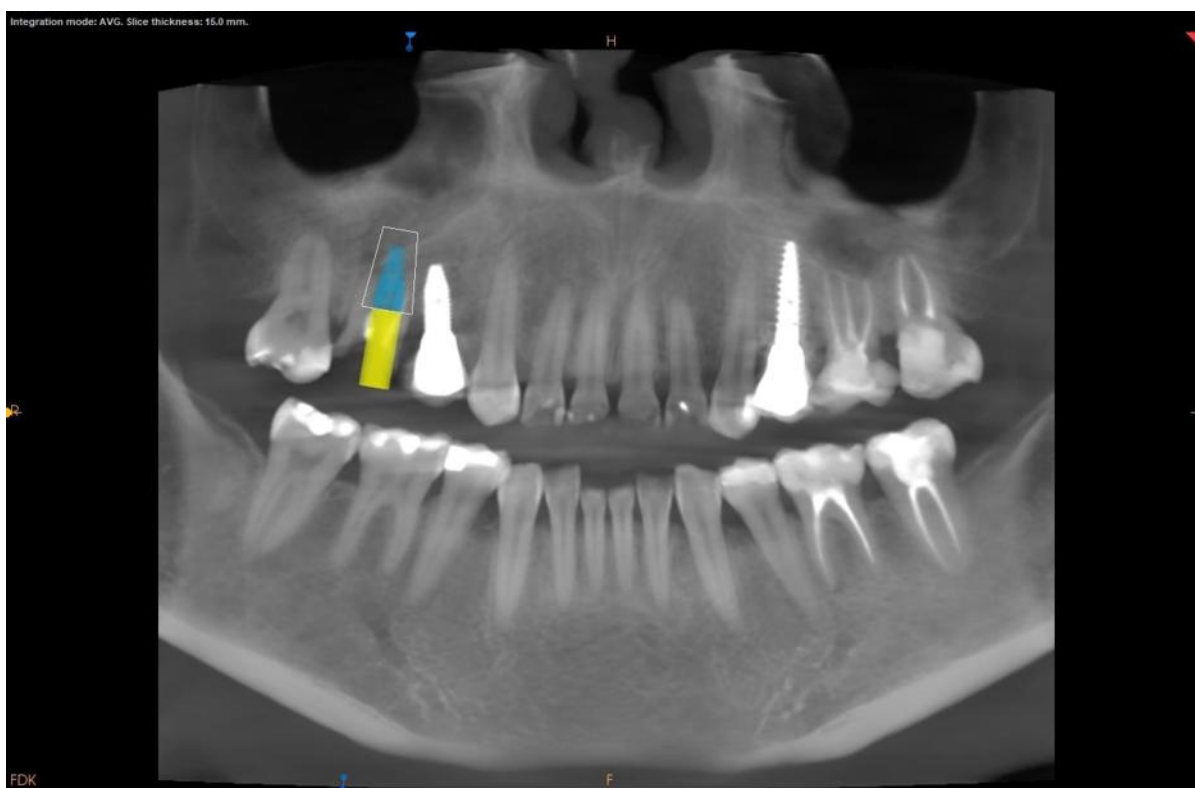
CBCT panoramic reconstruction showing virtual implant planning for tooth 16 (UR6).
